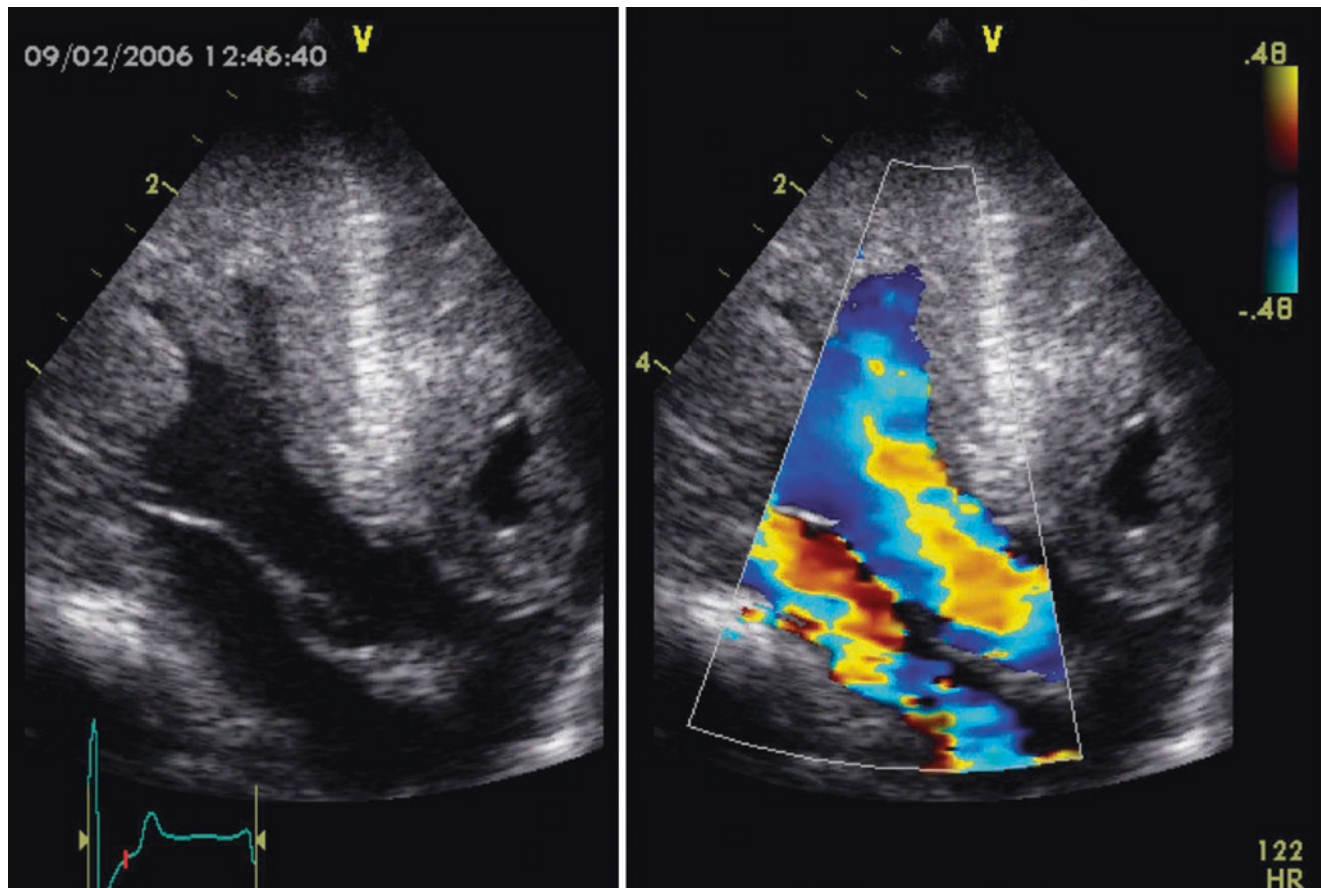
Echocardiography obtained in a newborn patient affected by Pompe disease. The image is dominated by a massive left ventricular hypertrophy. Colour Doppler mapping demonstrates a significant mitral regurgitation (courtesy J. Marek, Great Ormond Street Hospital, London, UK)
